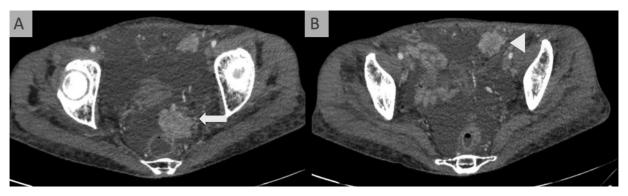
Peritoneal carcinomatosis in esophageal cancer. (A and B) Axial contrast-enhanced computed tomography (CT) scan shows heterogeneously enhancing mass in the pouch of Douglas (arrows) and left iliac fossa (arrowhead) with ascites.
